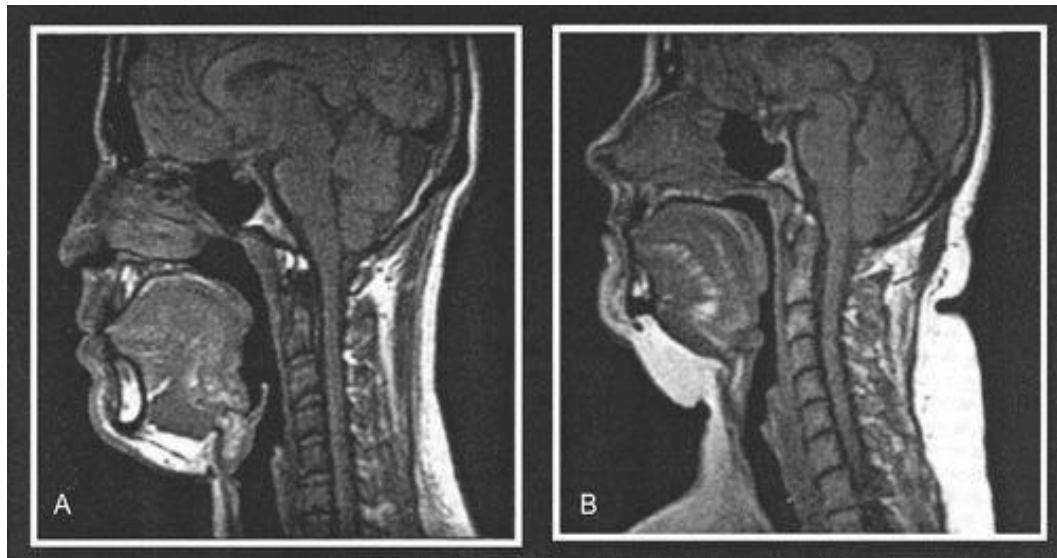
X-rays for the normal person and the obese person
